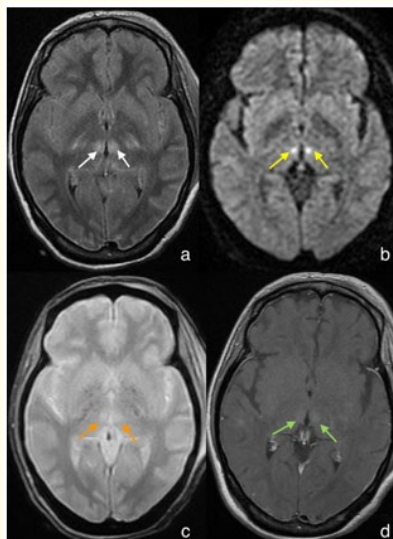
Patient 6: Brain MRI in axial planes in FLAIR sequence (a), diffusion (b), Echo Gradient T2 (c) and T1 after injection of Gadolinium (d) demonstrate bithalamic paramedian lesions described in high signal in FLAIR, restrictive in diffusion and show a mild enhancement.
